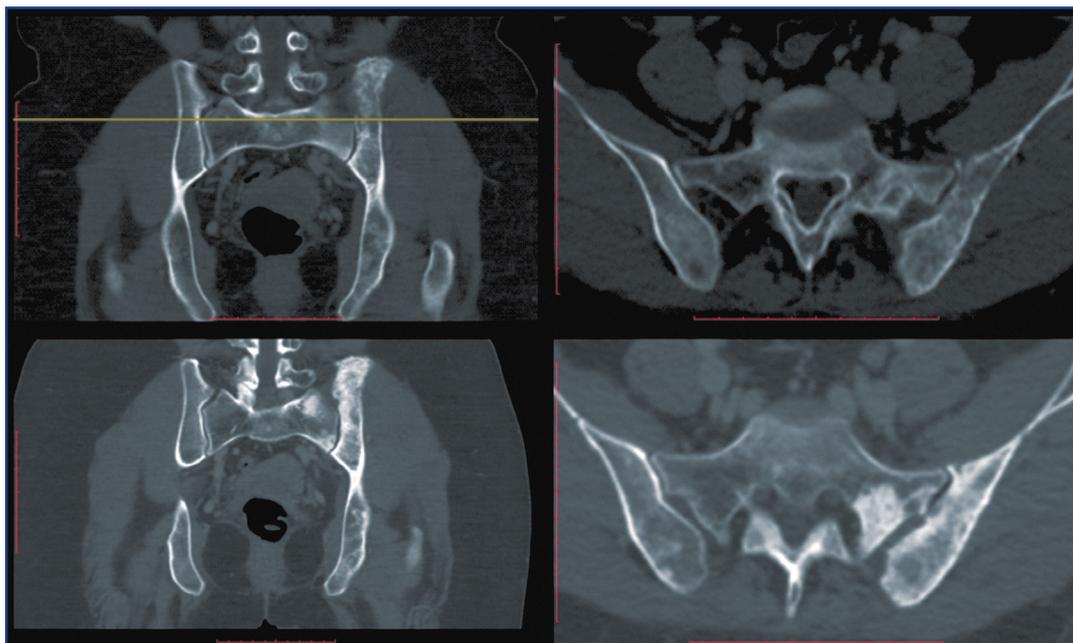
CT of the skeleton bones from October 2018 in comparison with July 2018. Stabilization of the process with positive dynamics in the form of further sclerotherapy of lytic sites of destruction.
